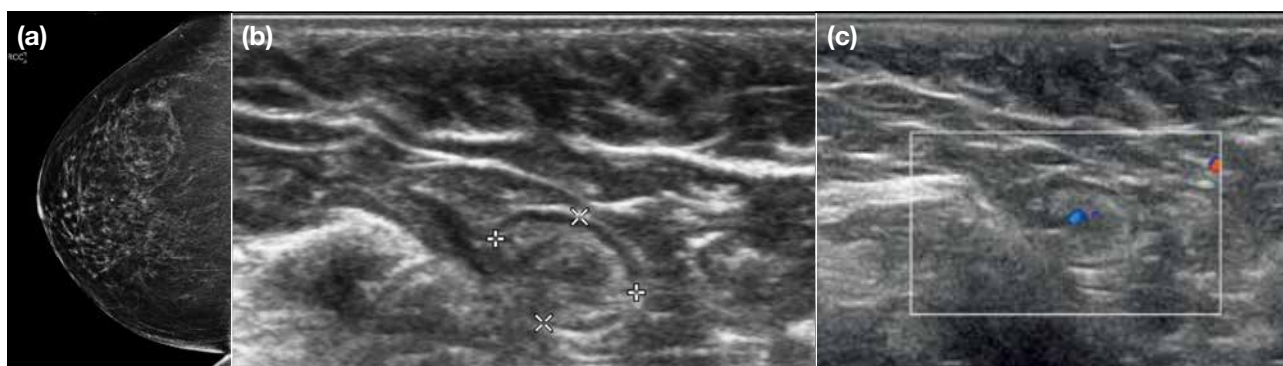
(a) Right craniocaudal mammogram of a 76-year-old woman showing a round circumscribed equal density lesion with a lucent centre at the outer part of the breast. (b, c) Ultrasonogram of the right upper outer breast showing a corresponding oval circumscribed echogenic lesion with thin hypoechoic rim. Hilar vascularity is present. Mammographic and sonographic features are typical of intramammary lymph node.
